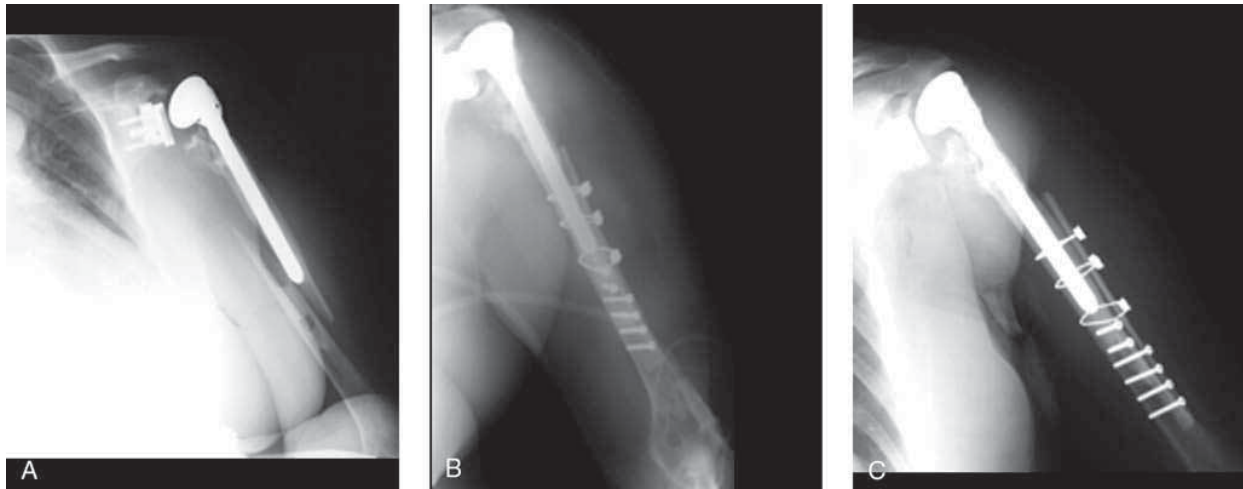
A, AP radiograph showing a type A periprosthetic fracture and a well-fixed humeral component. The fracture extends through the bone and cement mantle. (Reprinted with permission from Kumar S, Sperling JW, Haidukewych GH, Cofield RH: Periprosthetic humeral fractures after shoulder arthroplasty. *J Bone Joint Surg Am* 2004;86:680-689.) B, AP radiograph showing fracture fixation using a cortical allograft, screws, and cables. C, AP radiograph showing fracture healing 4 months after surgery. The cortical strut has not incorporated into the repair.
